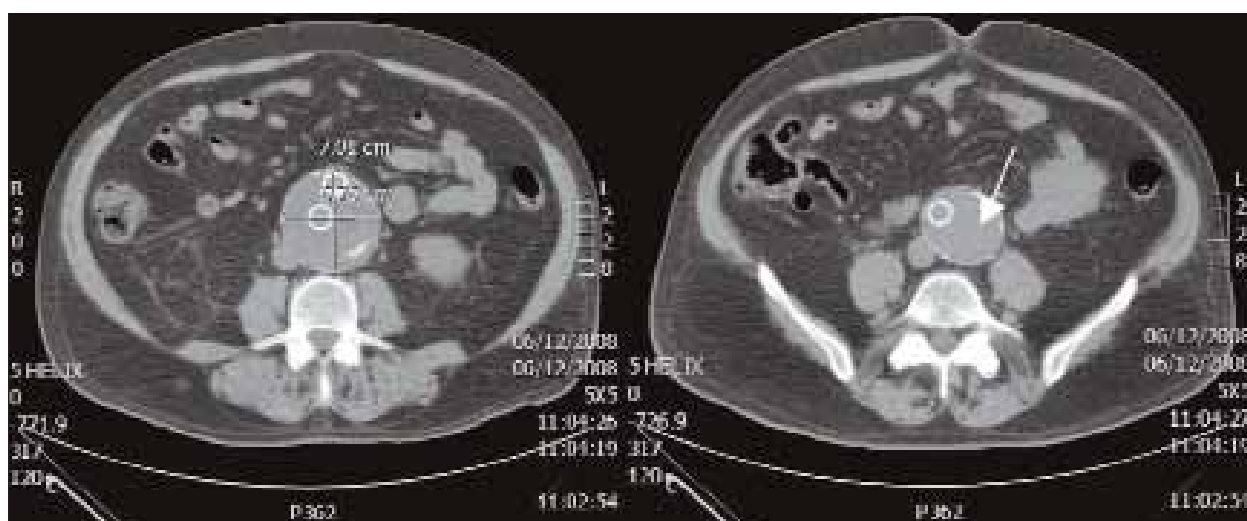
Abdominal computed tomography of type III endoleak due to graft separation. Note that only the right iliac limb is visible with the modular separation of the left iliac limb (white arrow).
